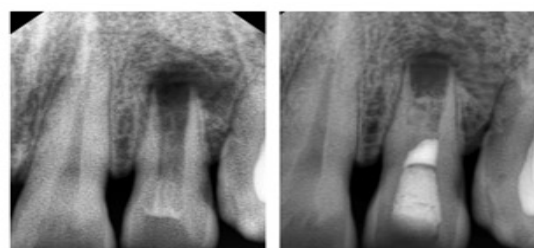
(a) Pre-op radiograph (b) Post-op radiograph after 1 year follow up
